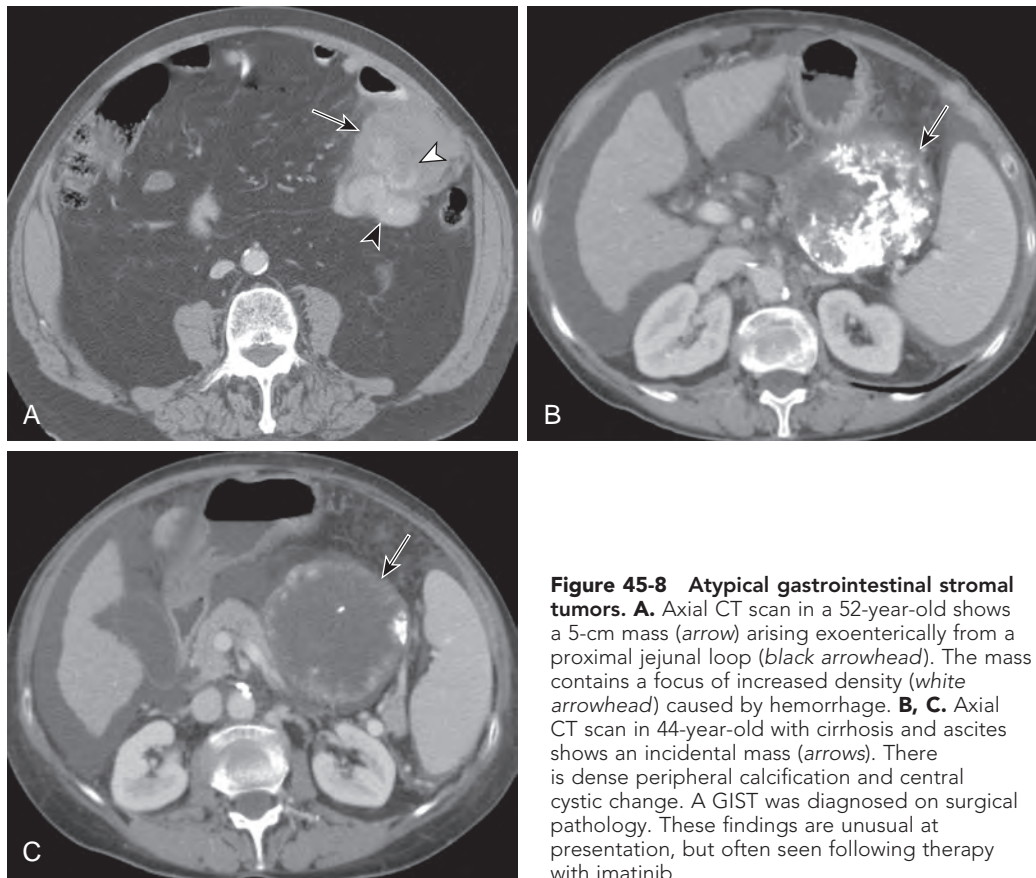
Atypical gastrointestinal stromal tumors. A. Axial CT scan in a 52-year-old shows a 5-cm mass (arrow) arising exoenterically from a proximal jejunal loop (black arrowhead). The mass contains a focus of increased density (white arrowhead) caused by hemorrhage. B, C. Axial CT scan in 44-year-old with cirrhosis and ascites shows an incidental mass (arrows). There is dense peripheral calcification and central cystic change. A GIST was diagnosed on surgical pathology. These findings are unusual at presentation, but often seen following therapy with imatinib.
